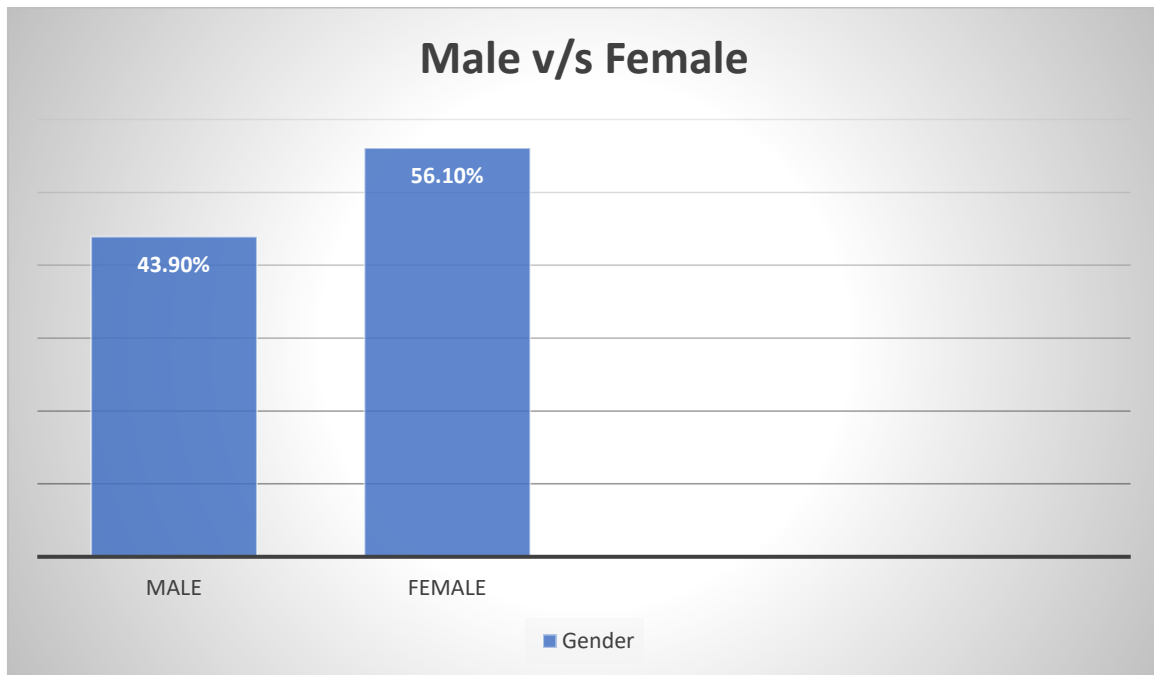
Gender-wise distribution of implant patients referred for CBCT evaluation.
